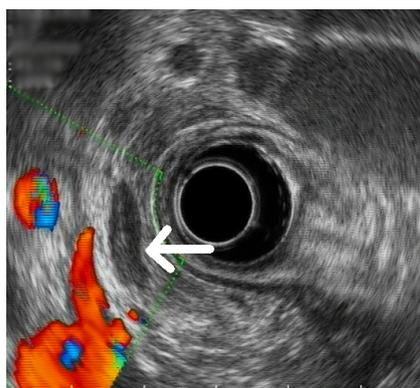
Endoscopic ultrasound showing 12.5-mm lymph node in the hepato-duodenal ligament
